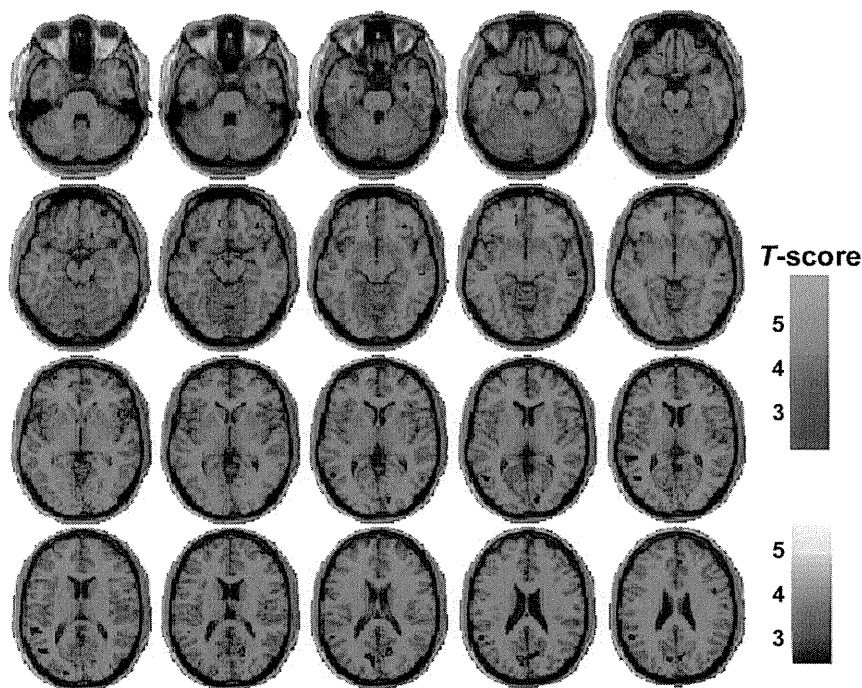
Effects of the risk-T-allele on decreased GM regions and diagnosis-*NRG1* genotype interaction on GM regions. Effects of the risk T allele on decreased GM regions (TT<CT<CC) in total subjects were shown by whinter colormap (blue areas). Diagnosis-*NRG1* genotype interaction on GM regions was shown by hot colormap (red areas). There was no significant effect of the risk T allele on increased GM regions (CC<CT<TT) among the total subjects. Each colormap shows t values corresponding to the color in the figure.
